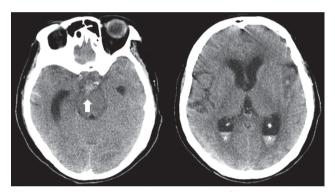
Brain computed tomography (CT) showed acute intraventricular hemorrhage (IVH) retention within bilateral lateral ventricles (stars) with some acute subarachnoid hemorrhage (SAH) within the preportine cistern (arrow).
